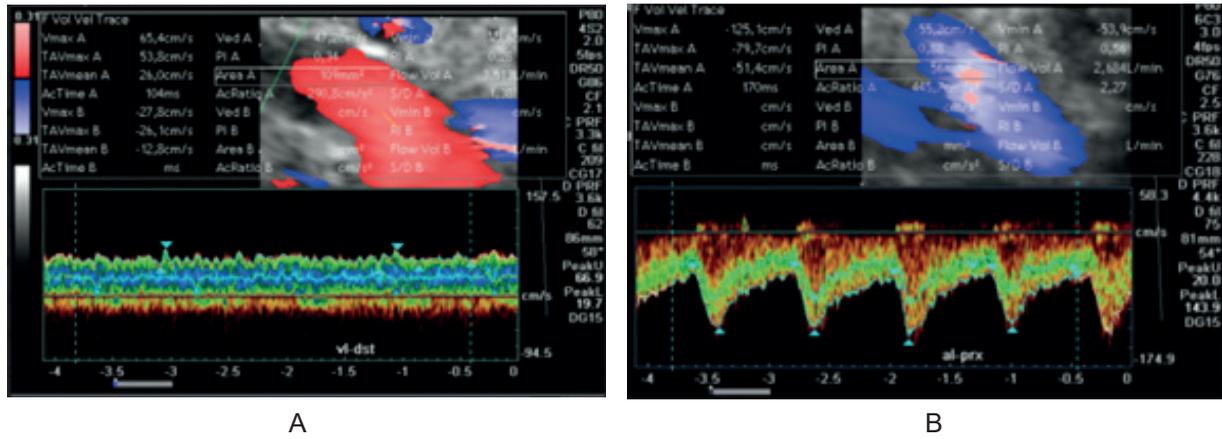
Methodology of Doppler hemodynamic assessment of splenic vessels: A – assessment of venous blood flow in the splenic vein (measurement of maximum velocity Vmax); B – spectral Doppler of the splenic artery (measurement of PSV and EDV, calculation of RI and PI indices)
